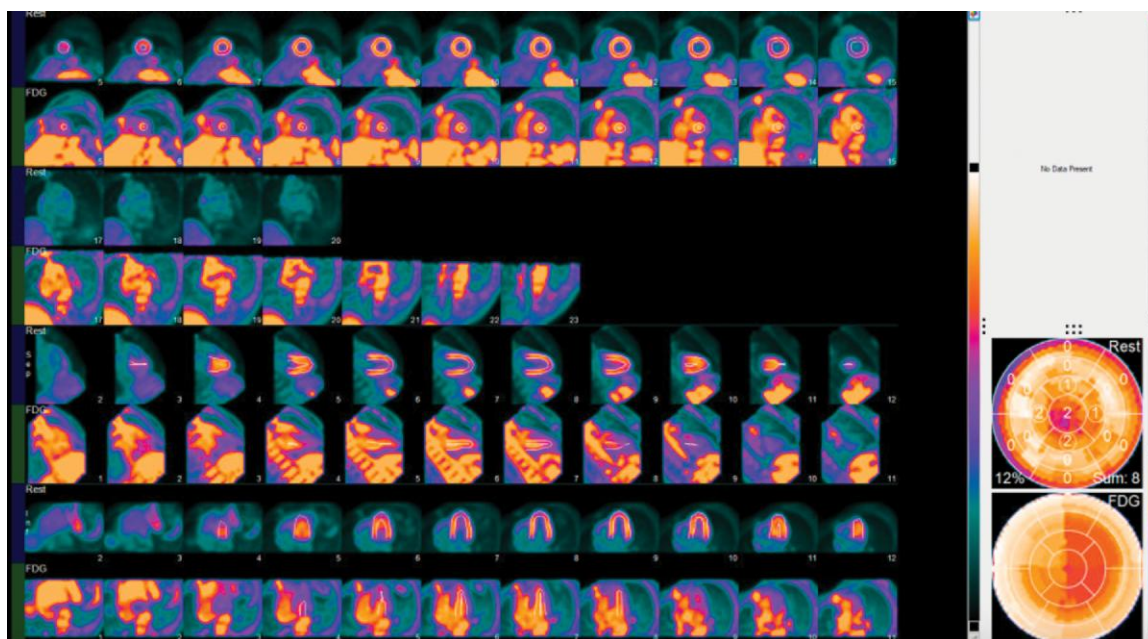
Follow-up FDG-cPET. A follow-up scan performed several months following the initiation of immunosuppressive treatment demonstrated that the initial FDG-avid foci in the right atria were no longer visible. FDG-cPET, ^{18}F -fluorodeoxyglucose-positron cardiac positron emission tomography.
